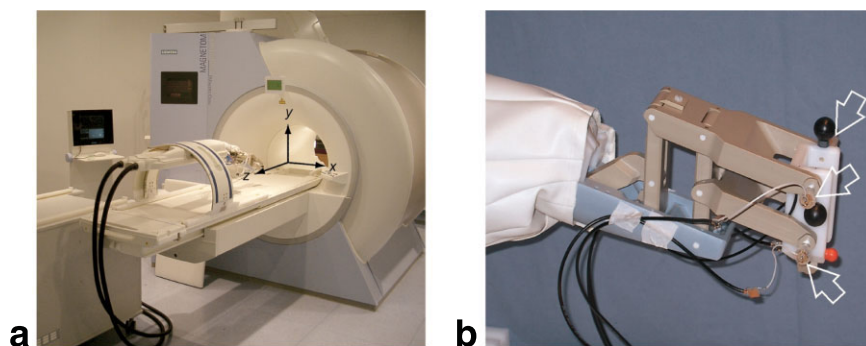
a: Fully MR-compatible robotic assistance system for percutaneous interventions mounted on the patient table of a 1.5 T closed-bore MR system. The robotic arm can be manually rotated by  $\pm 60^\circ$  on a fiberglass arc ( $1^\circ$  of freedom). Arm motion in the other 5 degrees of freedom is controlled by fully MR-compatible pneumatic drives. The robotic assistance system is coregistered with the MR laser reference so that in subsequent MRI experiments identical coordinate systems can be used for robotic motion and MRI. b: At the distal end of the arm a needle holder with passive markers (black spheres) and three active marker coils (open arrows) is attached.
